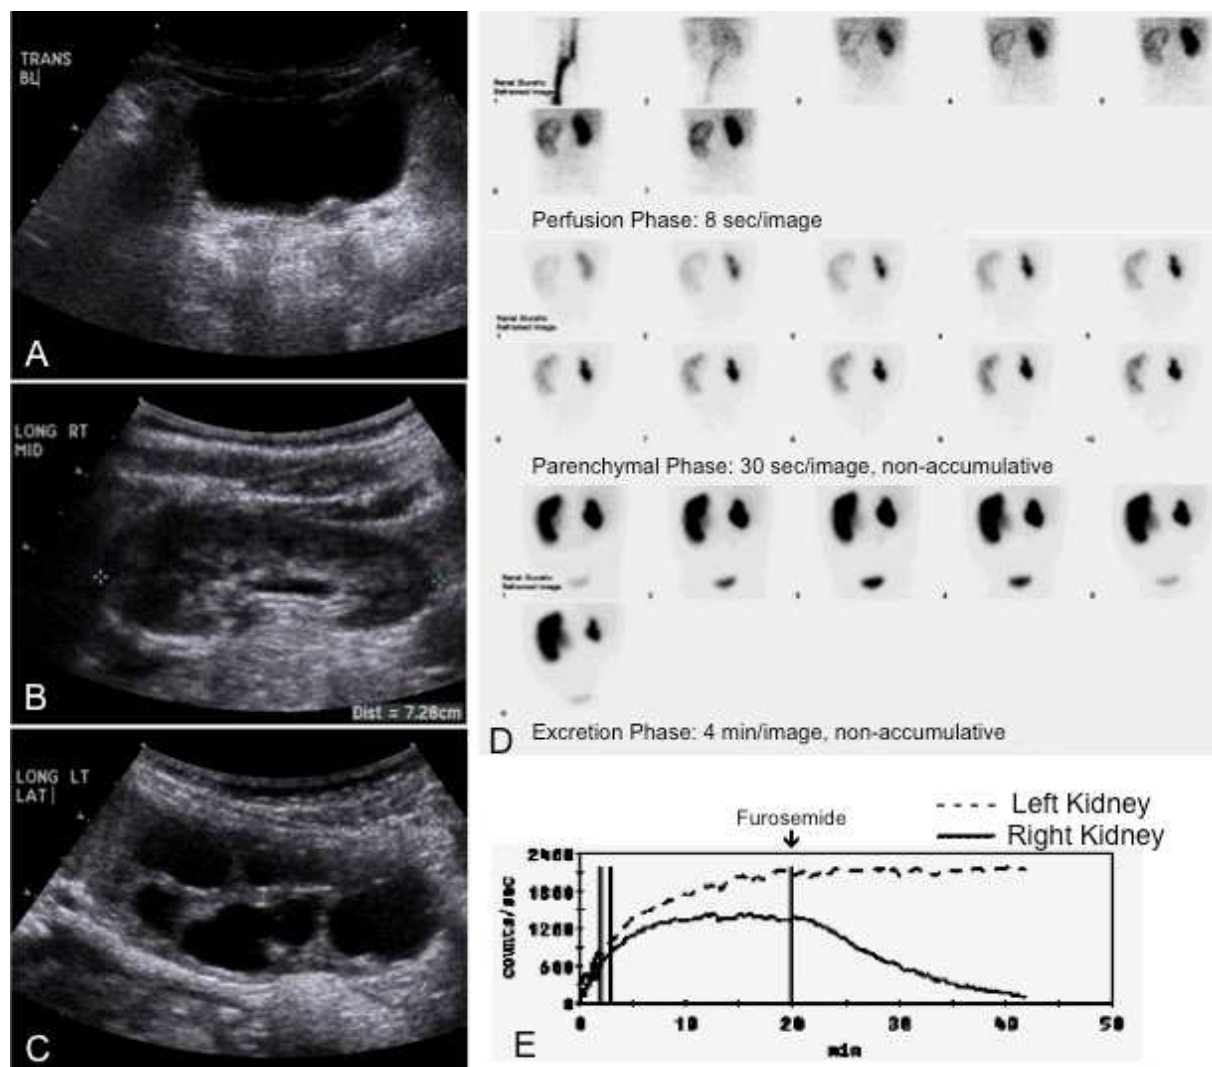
Radiological findings associated with UPJ obstruction in an 18 month old female. Left hydronephrosis was detected prenatally, and the patient had normal postnatal renal function with no vesicoureteral reflux (VUR). She was managed conservatively, with gradual improvement in hydronephrosis on serial imaging studies through age 15 months. However, at 18 months of age hydronephrosis worsened. A - C. Ultrasound of urinary bladder (A), right (B) and left (C) kidneys. The bladder (A) is normal in conformation with normal wall thickness, and no hydroureter is seen. The right kidney (B) is structurally normal with slight pelviectasis. The left kidney (C) demonstrates marked hydronephrosis with blunted calyces and thinned parenchyma, which had worsened from previous findings of moderate but improving hydronephrosis. D and E. Technetium-99m MAG3 diuretic renal scan using the F+20 protocol confirmed a left ureteropelvic junction obstruction. Sequential posterior images of the abdomen and pelvis (D) are grouped into perfusion, parenchymal, and excretion phases. Ten milligrams of furosemide were administered 20 minutes after tracer injection. With injection of the tracer, there is bolus visualization of the inferior vena
